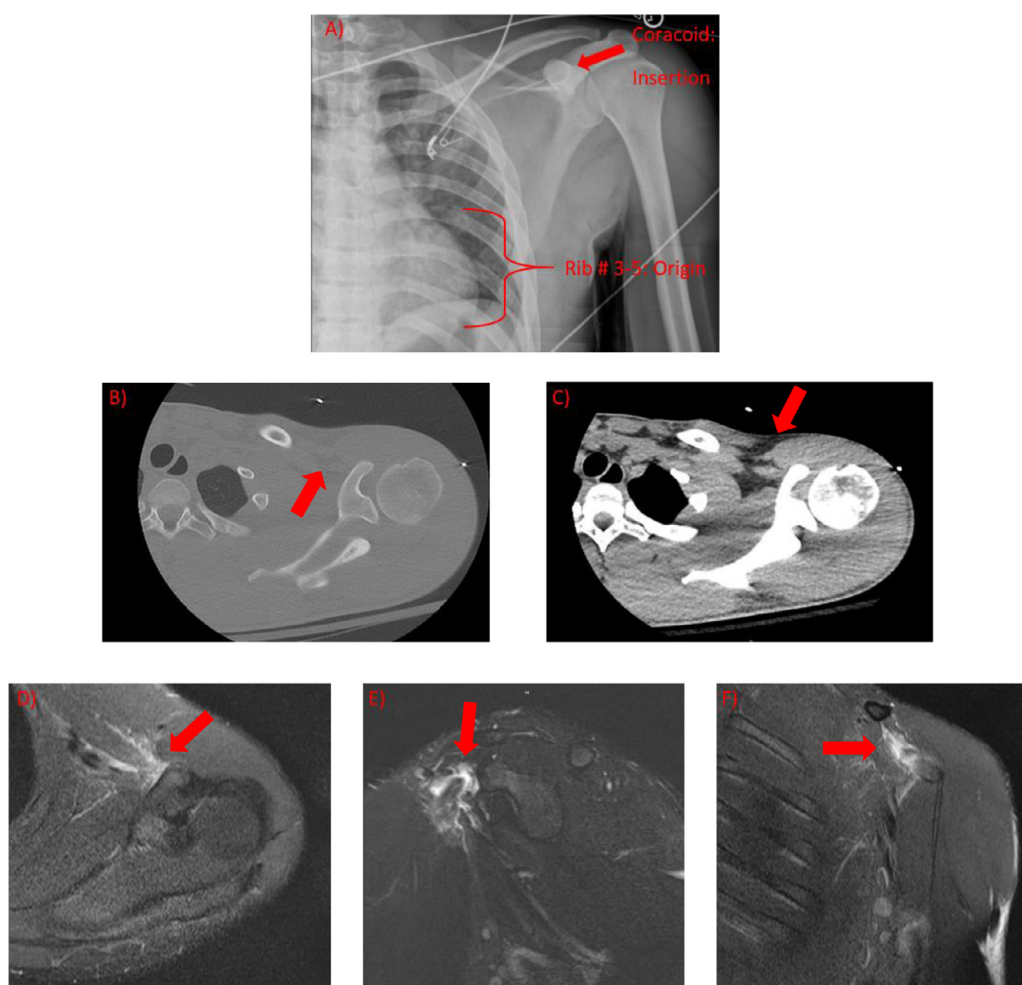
(A) Anteroposterior (AP) radiograph of the left upper extremity shows an intact coracoid process. The insertion (external surfaces of anterior portion of third to fifth rib) and the origin (coracoid process) of the pectoralis minor muscle are labeled. (B) Axial computerized tomography (CT) image (bone window) of the coracoid demonstrates no avulsion fracture. (C) Axial CT image of the coracoid (soft tissue window) clearly shows the pectoralis minor muscle and minimal surrounding fat stranding indicative of the tendon tear in retrospect. (D) Axial proton-density fat saturation magnetic resonance imaging (MRI) demonstrates edema and fluid signal (red arrow) of the pectoralis minor tendon attachment onto the coracoid process indicating a partial-thickness nonretracted tendon tear. (E) Sagittal T2 fat saturated MRI shows the insertion of the pectoralis minor tendon with significant muscle edema (red arrow). (F) Coronal proton-density fat saturation sequence MRI demonstrates pectoralis minor peritendinous fluid and edema (red arrow). (For interpretation of the references to color in this figure legend, the reader is referred to the web version of this article.)
